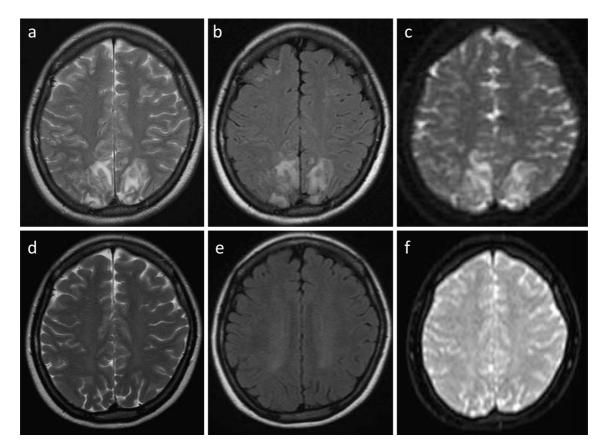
Head MRI scans on admission (a-c) and after treatment (d-f). T2-weighted imaging (a, d), fluid-attenuated inversion recovery (FLAIR) (b, e), and apparent diffusion coefficient (ADC) maps (c, f).
